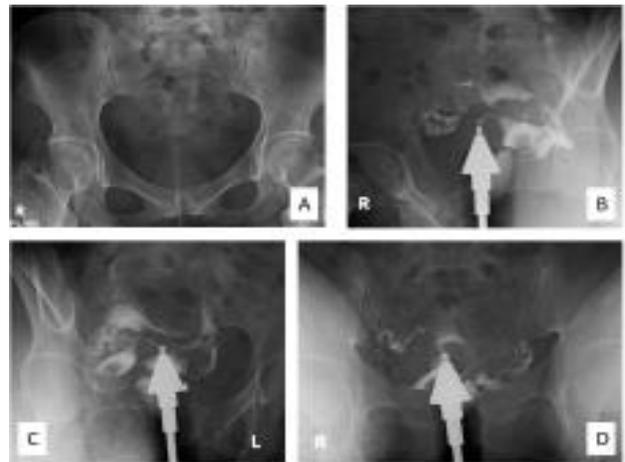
Leiomyoma uterine (A): Plain radiograph. (B), (C), (D): Contrast fills the uterine cavity, both fallopian tubes, with right and left peritoneal spillage. The cervical canal appears normal with regular margins. The uterine cavity is in a retroflexed position, with a rounded filling defect on the anterior uterine body, characterized by well-defined, smooth edges.
